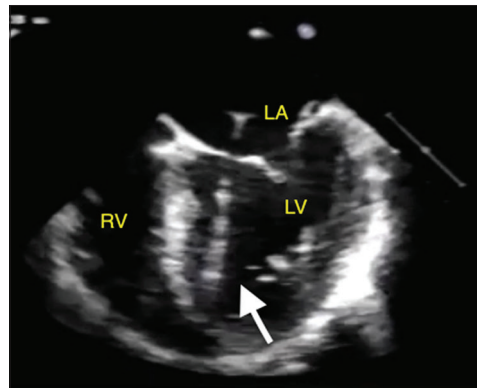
Transesophageal echocardiogram mid-esophageal four-chamber view demonstrating a pacer wire in the left atrium and left ventricle (arrow). LA: Left Atrium, LV: Left Ventricle, RV: Right Ventricle
